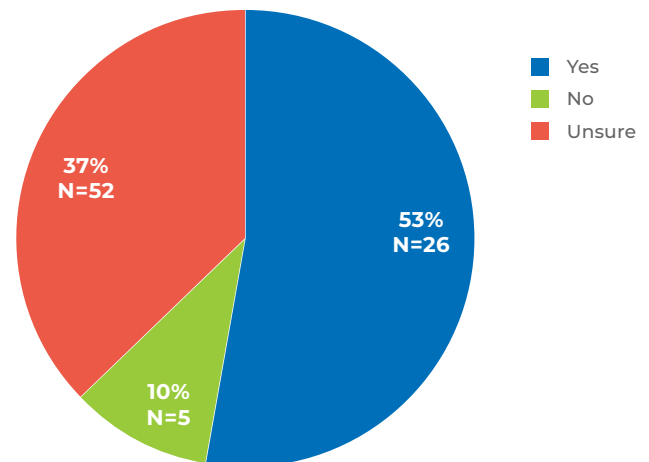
Awareness of Current Radiographic Guidelines for LBP
